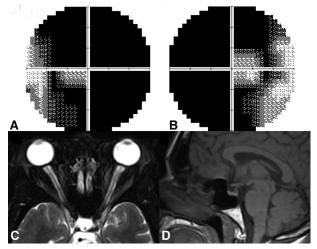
Case 2. Humphrey visual field 30-2 demonstrating severe constriction of the left (A) and right (B) visual fields. (C) T2 axial MRI image showing enlargement of the CSF spaces in the optic nerve sheaths and flattening of the posterior globes. (D) T1 sagittal MRI image showing partially empty sella, with mild concavity of the superior pituitary gland. CSF, cerebrospinal fluid.
